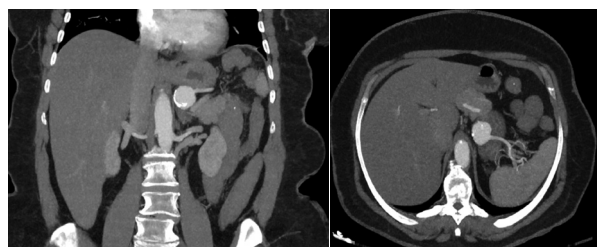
CTA revealing splenic artery aneurysm
